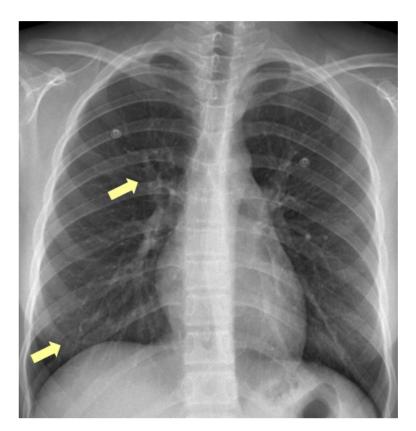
Chest X-ray showed suspicious nodular opacities at RUL and RLL
